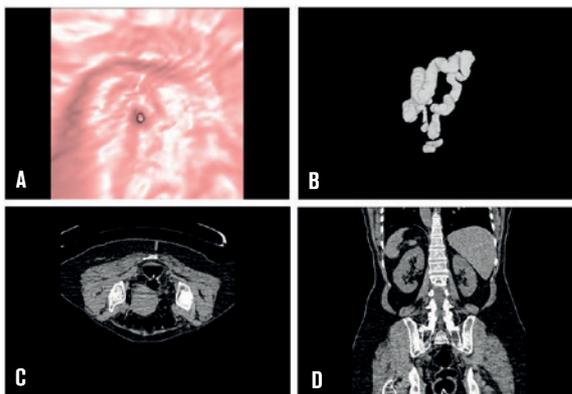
A 52 year-old female patient who underwent segment resection for giant polyp at rectosigmoid junction 2 years ago, the anastomotic junction could not be through passed during follow-up conventional colonoscopy. 3D endoluminal (A) image demonstrating remarkably narrowed lumen at 10th cm from rectum and CT colonographic (B) image demonstrating significant interruption of the air column. Stricture at the anastomosis leading to remarkable narrowed lumen and metallic densities at the wall belonging to clips material seen at axial (C), coronal MPR (D) images. Pathological wall thickening was not detected at this location.
